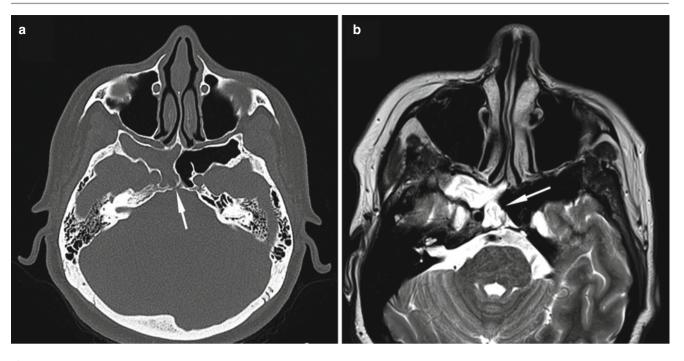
CSF leak. Axial noncontrast CT image (a) and noncontrast T2-weighted MR image (b) in a patient with a CSF leak arising from the clivus and presenting with right-sided rhinorrhea. CT imaging
